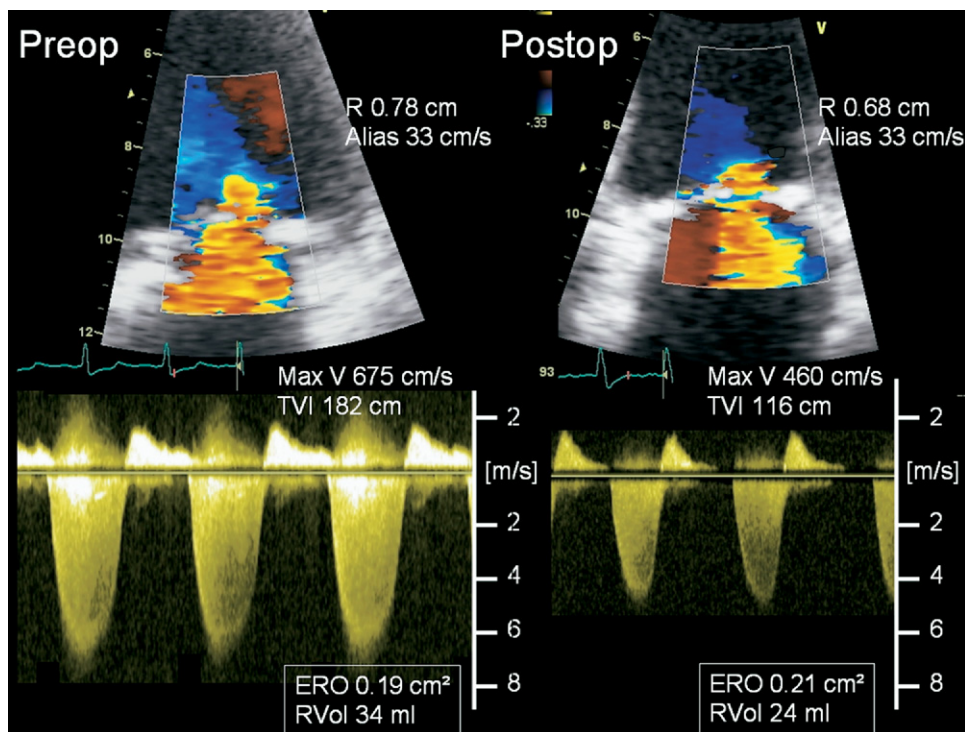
Example of changes in mitral regurgitation induced by aortic valve replacement. Apical 4-chamber view showing proximal flow-convergence region at baseline (*Preop*) and after aortic valve replacement (*Postop*), and typical pattern of regurgitant volume (*Rvol*) reduction. There is no significant change in calculated effective regurgitant orifice (*ERO*), whereas regurgitant volume markedly decreases as a result of reduction in the time velocity integral (*TVI*) of regurgitant jet. R = proximal isovelocity surface area (PISA) radius; Alias = aliasing velocity; Max V = maximal regurgitant flow velocity.
